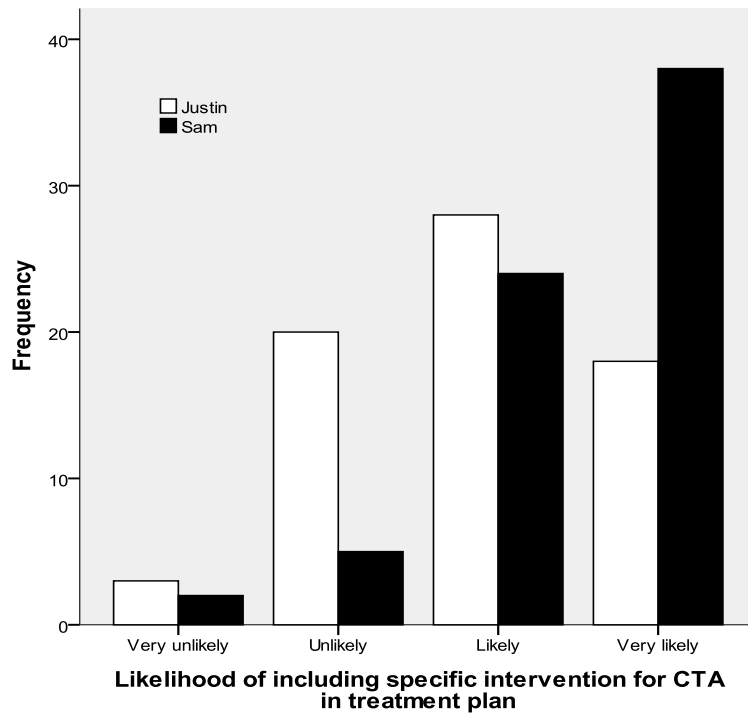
Likelihood of including a specific intervention for disclosed CTA in a subsequent treatment plan across both vignettes.
